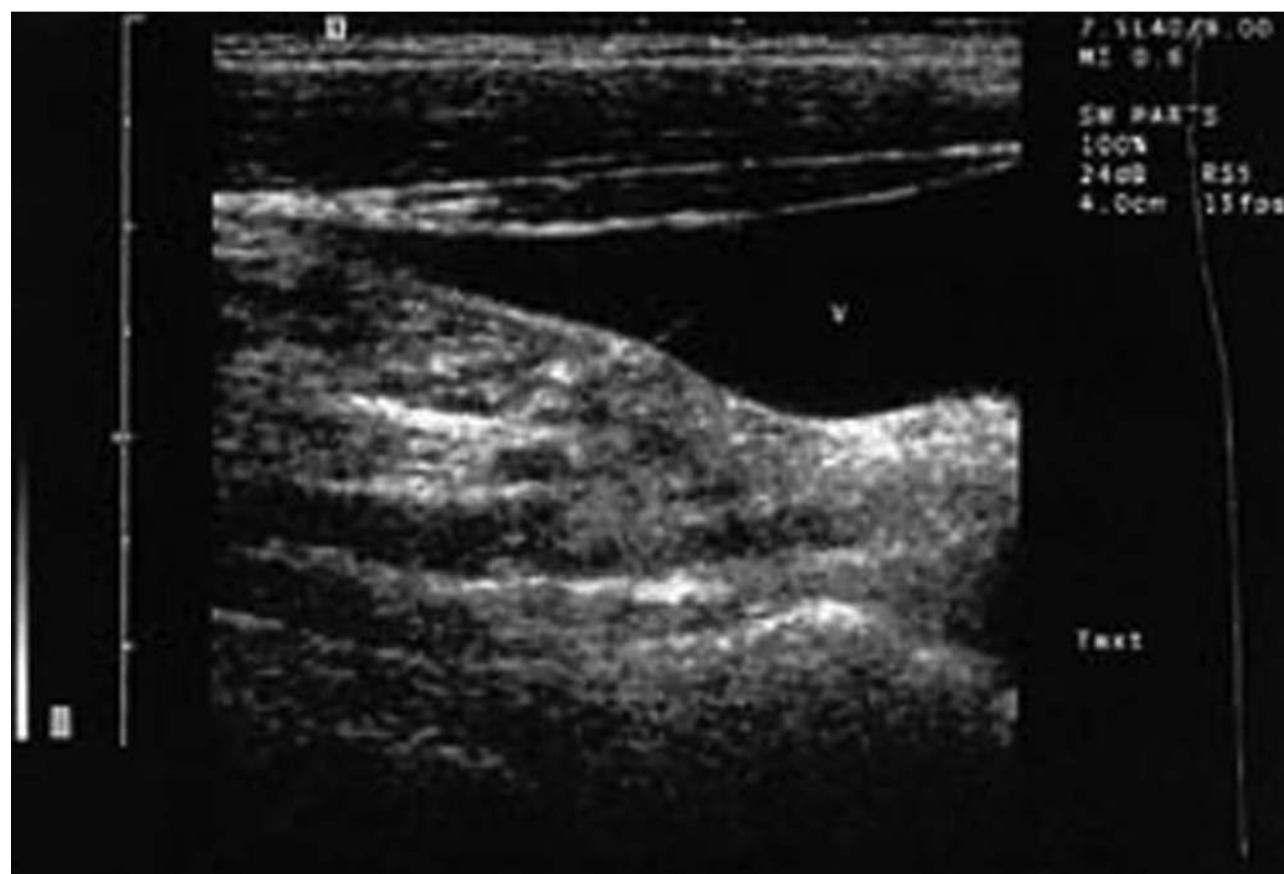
Estimating jugular venous pressure. An ultrasound longitudinal view of the internal jugular vein shows tapering at the point of jugular venous pulsation. (Reproduced with permission from Lipton B. Estimation of central venous pressure by ultrasound of the internal jugular vein. *Am J Emerg Med.* 2000 Jul;18(4):432–434.)
